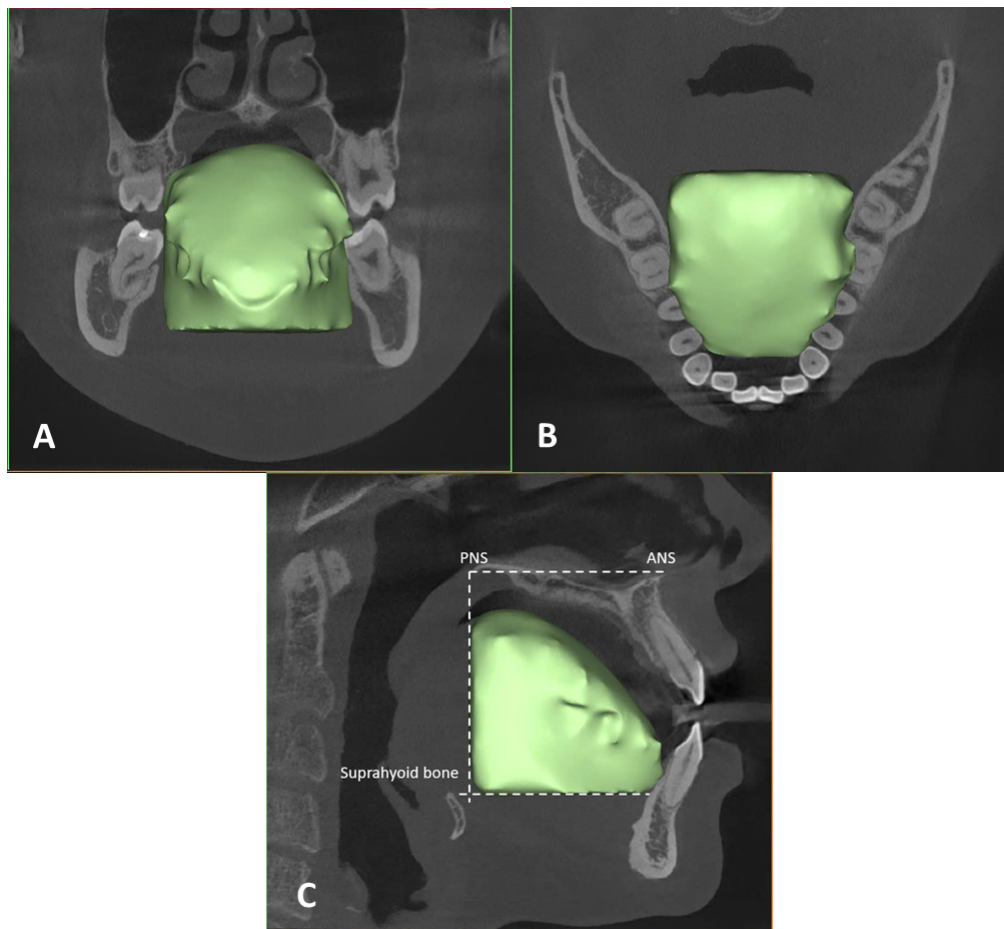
Assessment of TV on CBCT: (A) coronal plane, (B) axial plane and (C) sagittal plane. The plane that passes through the ANS and PNS was considered standard. The inferior border of the tongue was defined as the plane passing through the upper limit of the hyoid bone and parallel to the palatal plane. The posterior border of the tongue was determined by a line perpendicular to the PNS-ANS and a line parallel to the PNS-ANS and passing through the superior border of the hyoid bone. The front and upper parts followed the tongue's curvature in the OP. The tongue was manually separated with Hounsfield and gray values for the soft tissue scan tool. The inside of the tongue was smeared on each of the axial, coronal and sagittal planes, and the TV was calculated.
